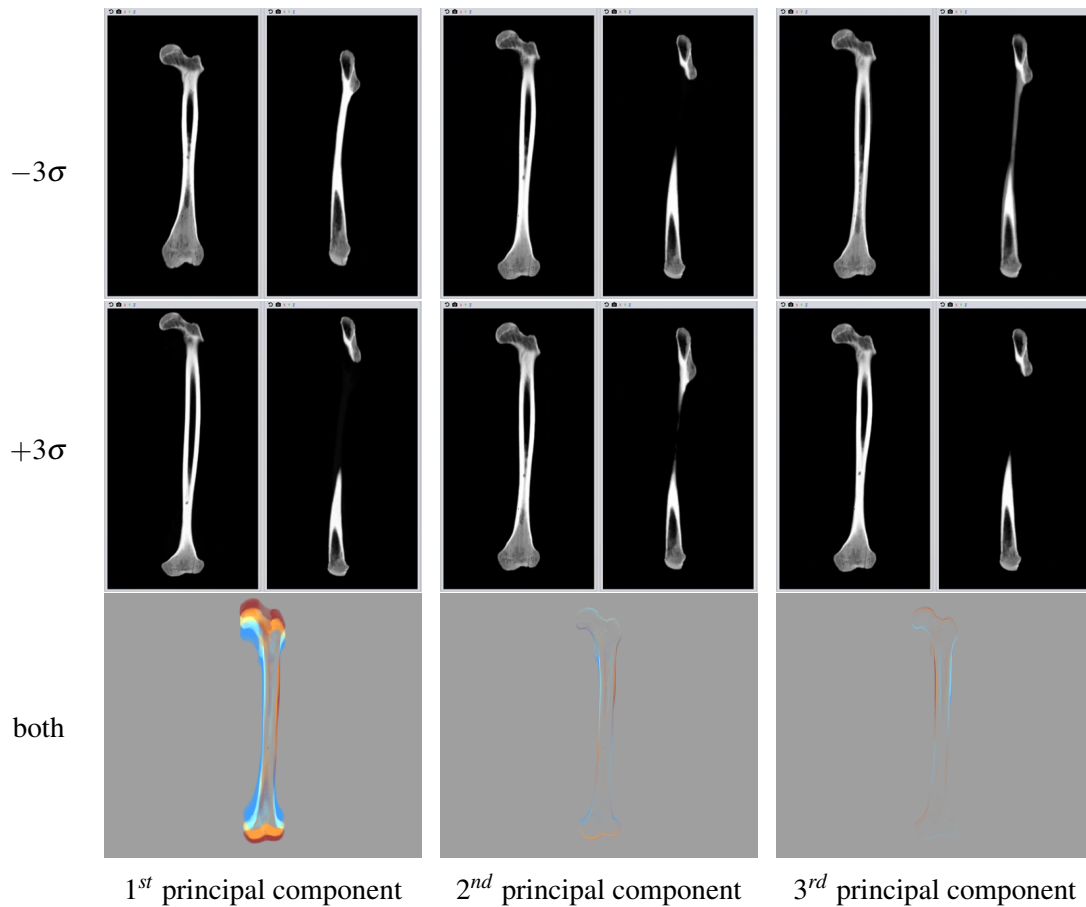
The first three principal components of the femur GPMM. The top row shows CT cross-sections (lateral and anterior-posterior) for each principal component with a parameter value of -3σ . The middle row shows CT cross-sections for each principal component with a parameter value of $+3\sigma$. Each item in the bottom row shows a difference image of DRRs corresponding to a parameter value of -3σ (blue) and $+3\sigma$ (orange). The mean is shown in white.
